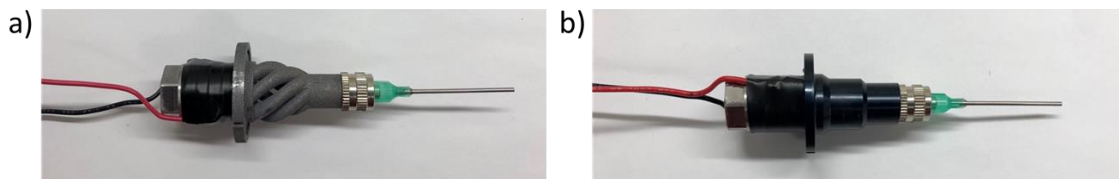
Prototypes of L&T ultrasonic transducer and longitudinal transducer.
